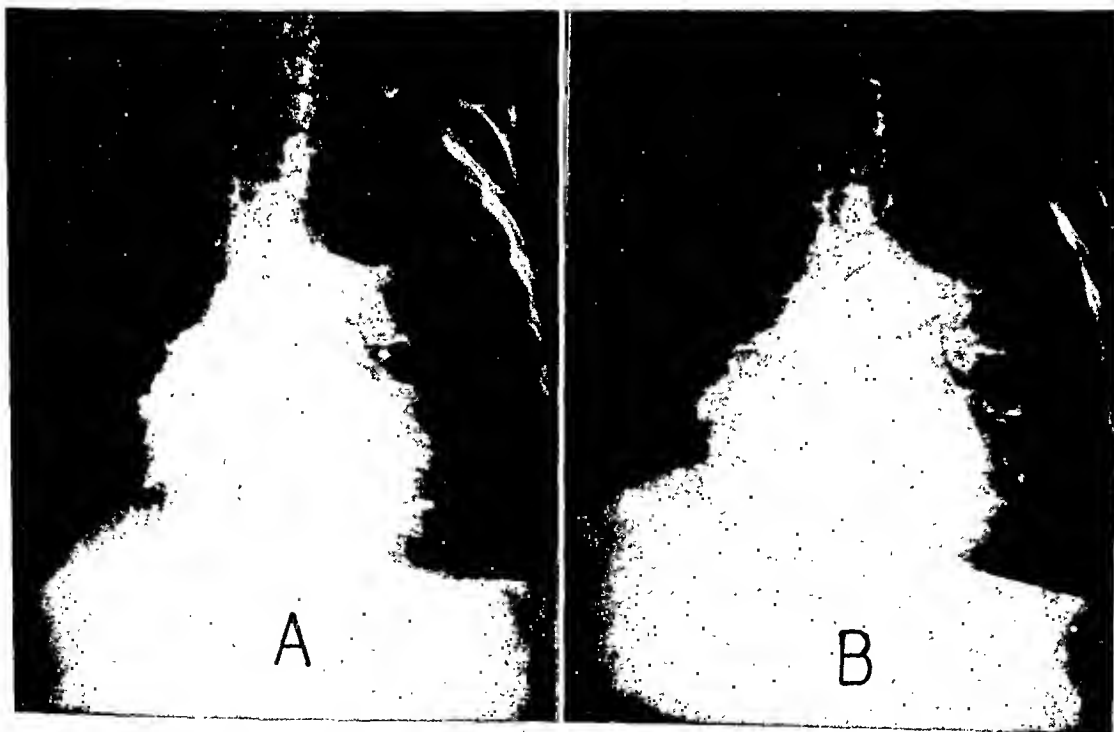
Over-exposed posteroanterior chest roentgenograms made after injection of 70 per cent diodrast. The pulmonary artery is well opacified in *A* and the shadow of the aorta is accentuated in *B*.
